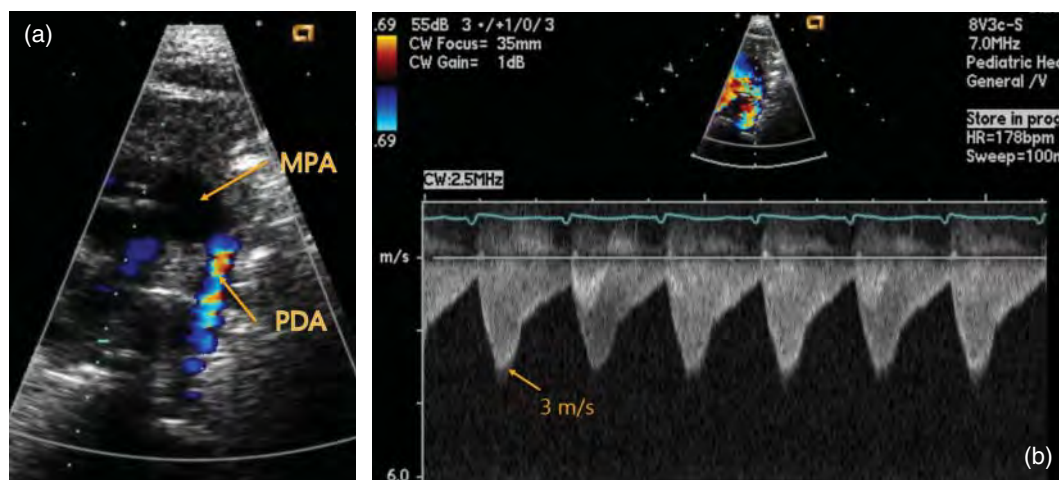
(a) Patient with pulmonary hypertension and a smaller PDA than in Figure 49.3. (b) Spectral Doppler image demonstrates a continuous systolic and diastolic right to left shunt, with systolic peaking. The Doppler profile is that of a saw-tooth pattern.
